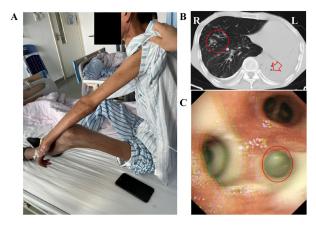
Images from a typical patient with M/XDR-TB. A 49-year-old man with a 10-year history of XDR-TB. Six months later, he died from respiratory failure. (A). The general appearance of the patient. He is suffering from malnutrition, dyscrasia, and chronic respiratory failure. He has almost lost the ability for self-care and he depends on a caregiver for his daily activities. (B). Chest CT findings suggest that the left lung is destroyed (red arrow) and that disseminated TB is present in the right lung (red ring). (C). Findings from tracheobronchoscopy. White purulent exudate and phlegm were visible, even in the bronchus (red circle). CT: computerized tomography; TB: tuberculosis; XDR-TB: extensively drug-resistant tuberculosis.
